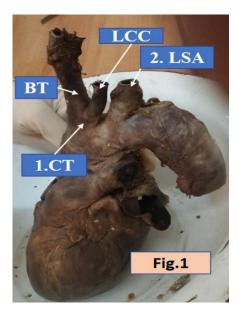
Type B variation, Two branches of arch of aorta with common trunk (CT)of brachiocephalic trunk (BT) and left common carotid artery (LCC), and Left subclavian artery (LSA).
